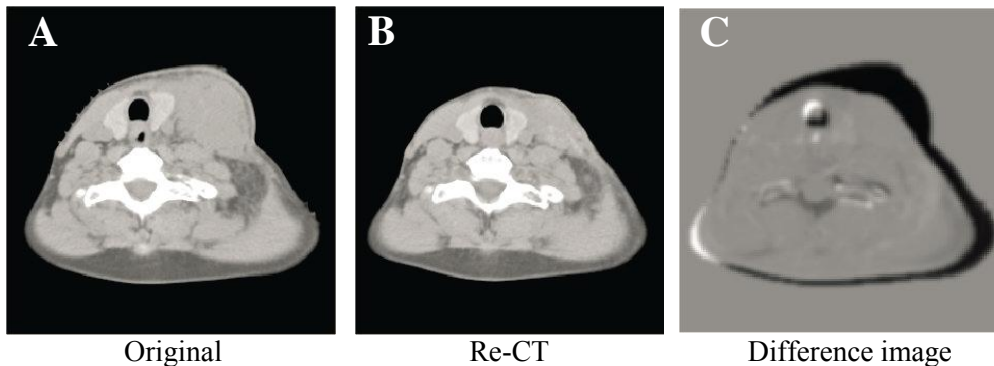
An example of anatomy change in a neck nodal region during radiotherapy. (A) The transversal slice of the original CT image. (B) The same slice of the re-CT image acquired 37 days after the start of radiotherapy. (C) The difference image of (A) and (B). There is clearly a visible shrinkage of the anatomy. Source: Wang et al. [71].
